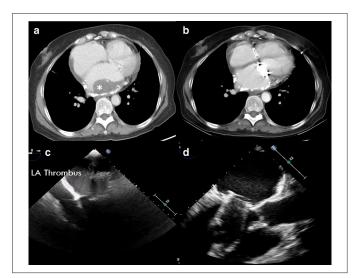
(a) Preoperative CT of thorax, * denotes the LA thrombus on the calcified atrial wall. (b) Follow-up CT thorax showing the left atrium with minimal atrial thrombus. Intraoperative transesophageal echocardiogram (c) before and (d) after thrombectomy. (c) LA thrombus and (d) left atrium largely free of thrombus. CT, computed tomography; LA, left atrial.
